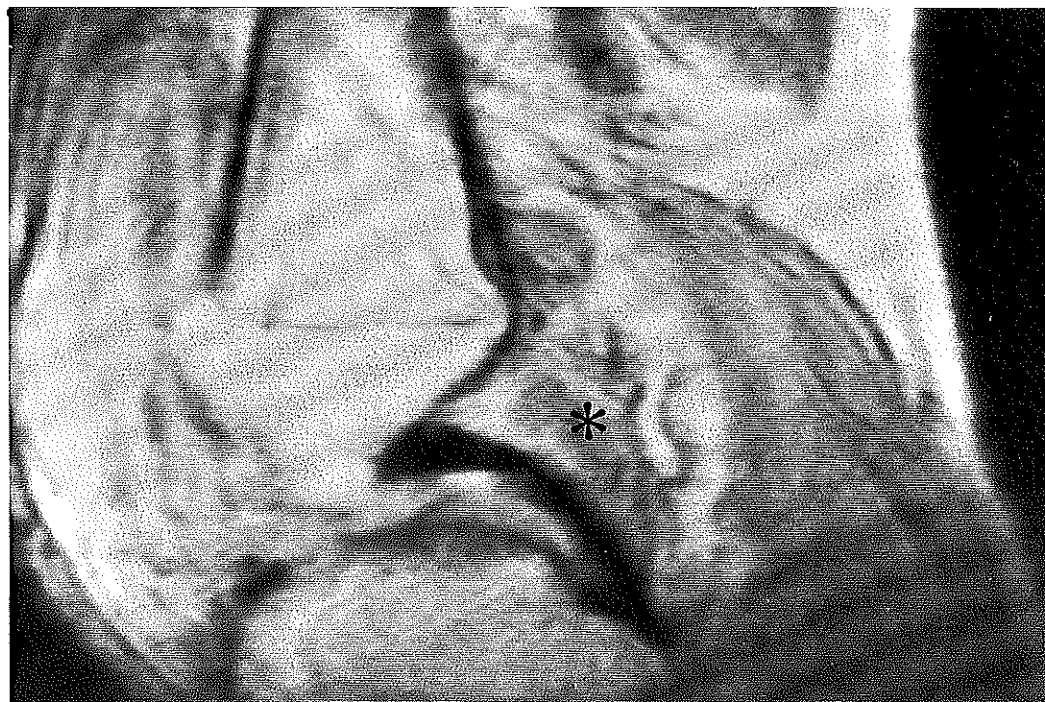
An 18-year-old man had knee pain and swelling. A sagittal T1-weighted MR image at the level of the posterior cruciate ligament. The joint was filled with an intermediate signal intensity tissue. Biopsy revealed pannus, which led to the diagnosis of RA.
